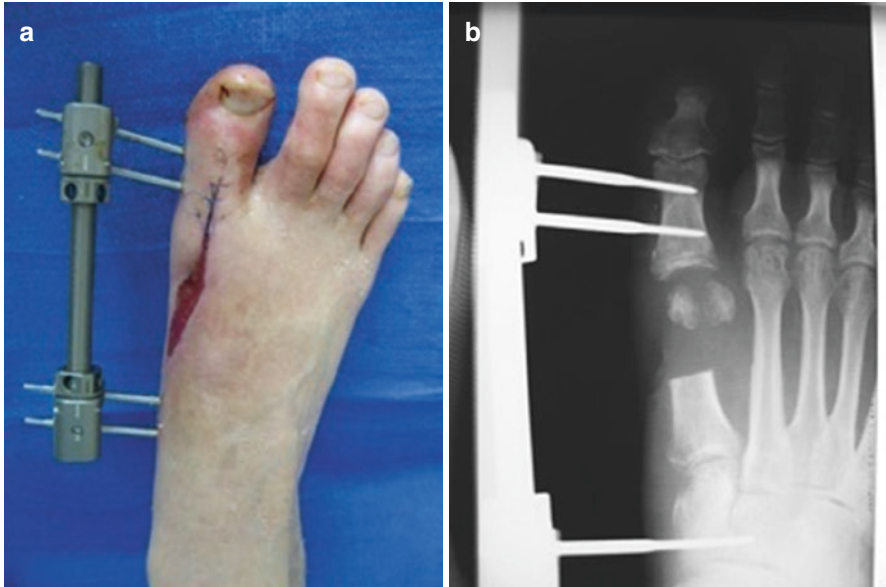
Clinical (a) and radiographic (b) image of external fixation used as a spacer
